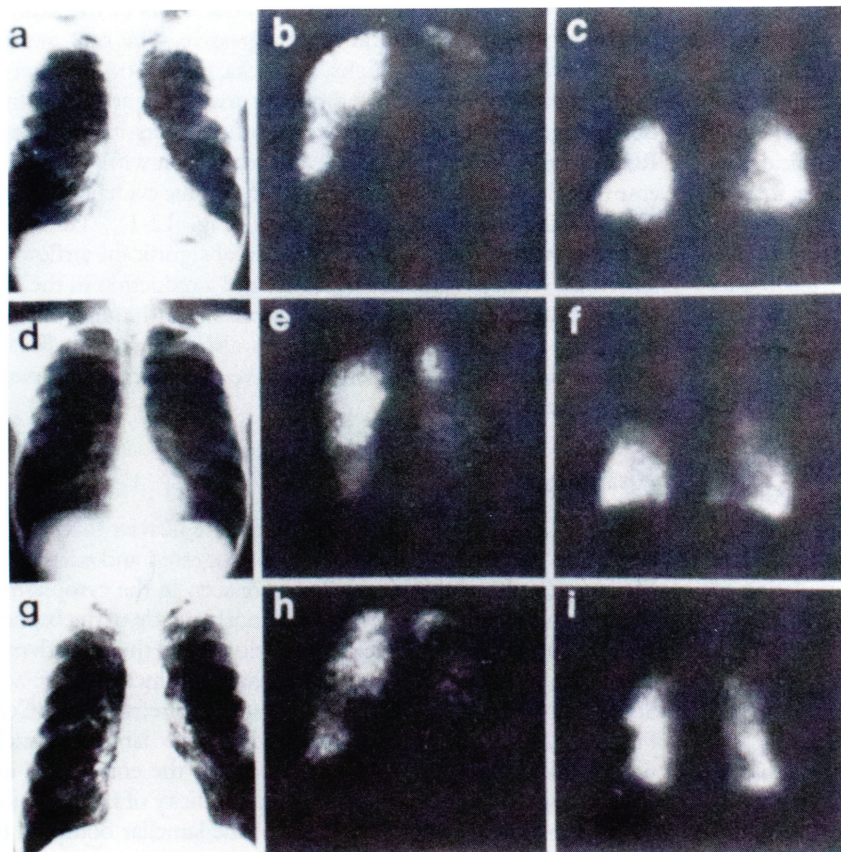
Chest roentgenograms and ventilation and perfusion scans of three patients with Fabry disease. (A) In the first patient, the chest roentgenogram demonstrated hyperinflation and bullae. (B) The ventilation image after 3 minutes of washout revealed marked retention in the upper right lung field, corresponding to the bullae seen on the chest roentgenogram. (C) The perfusion scan showed bilateral defects, particularly in regions of ventilation abnormalities. (D) In the second patient, the chest roentgenogram demonstrated hyperinflation. (E) The ventilation image after 3 minutes of washout demonstrated an inhomogeneity of tracer clearance, predominantly on the right side. (F) The perfusion scan showed defects in the region of ventilatory abnormalities. (G) In the third patient, the chest roentgenogram demonstrated hyperinflation with bullae formation. (H) The ventilation image after 3 minutes of washout showed marked retention in the right lung field, corresponding to bullae. (I) The perfusion scan demonstrated bilateral defects, particularly in regions of altered ventilation. (From Rosenberg DM, Ferrans VJ, Fulmer JD, et al. Chronic airflow obstruction in Fabry's disease. *Am J Med* 1980;68:898.)
